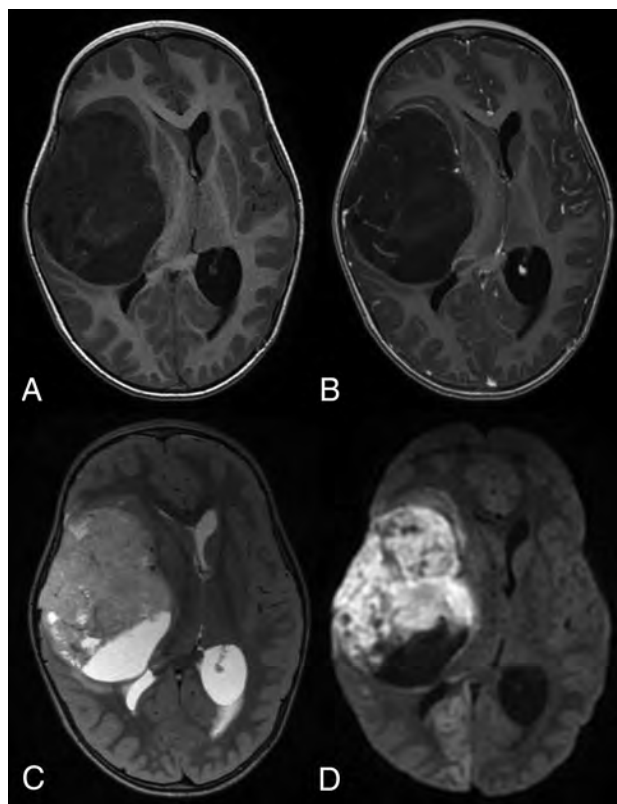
Brain imaging of patient 6. Axial plane MR images show a large heterogeneous right temporal tumor, with mass effect and midline shift. The tumor displays hypointensity on the T1-weighted image (A), hyperintensity on the T2-weighted image (C), and weak enhancement after contrast media injection (B). An intratumoral vessel is seen (B). Diffusion signal is high (D) with low ADC. Diffusion is also restricted in the right occipital lobe (D) because of an ischemic injury caused by compression of the posterior cerebral artery.
